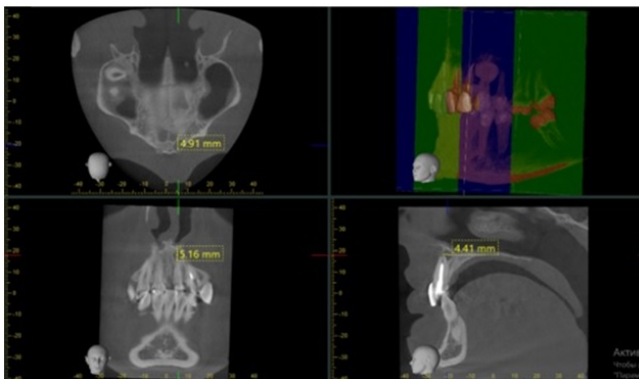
Cyst at the apex of the tooth root 21. CBCT, sagittal projection.
